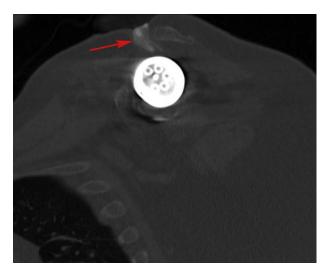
Sagittal CT arthrogram image of the left shoulder. Contrast agent is seen tracking superiorly from the joint and through the defect in the skin (red arrow).
